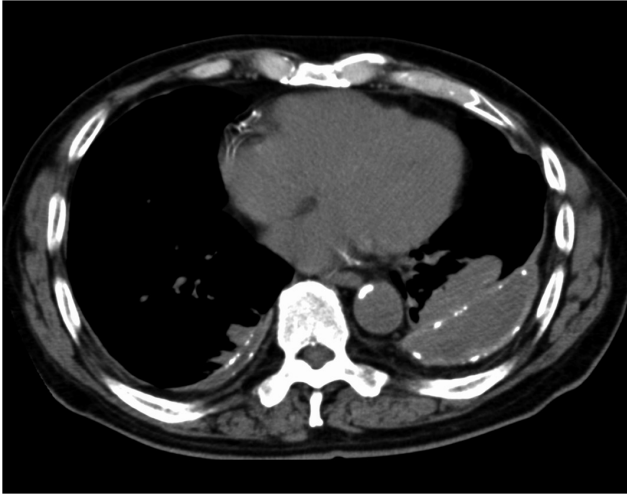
A cross-sectional chest computed tomography (CT) image showing a decline in chest capacity. A slightly heterogeneous pleural effusion with the tendency to be encapsulated was observed in both sides, and the left chest is smaller than the right chest.
